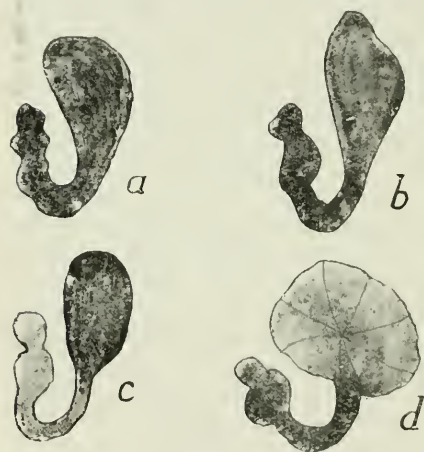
X-RAY PHOTOGRAPHS.
